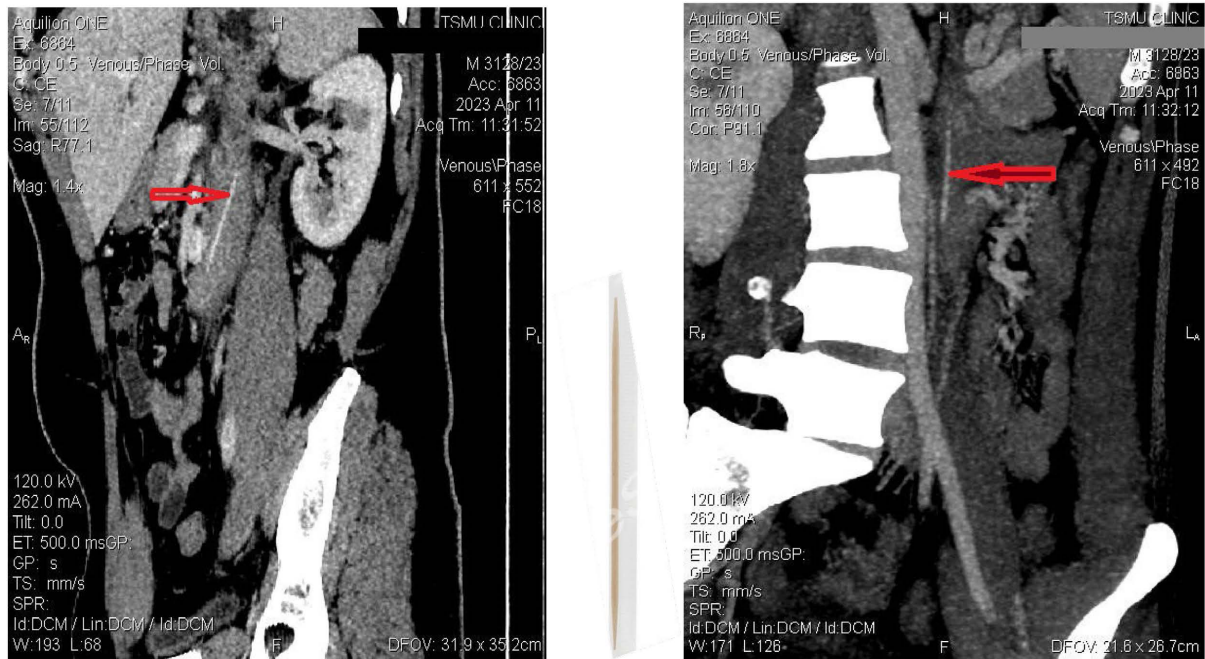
Abdominal computed tomography. A) sagittal reconstruction; B) toothpick; C) oblique coronal reconstruction. The arrow shows a high-density FB-a toothpick.
